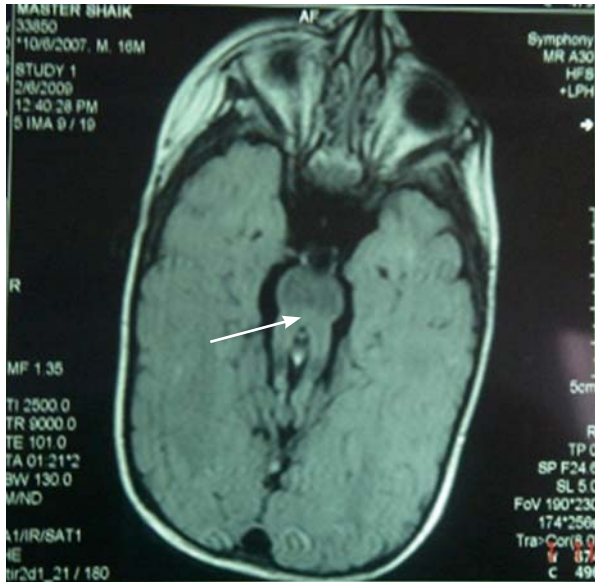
MRI of Brain Showing Molar Tooth Sign (White Arrowhead)
